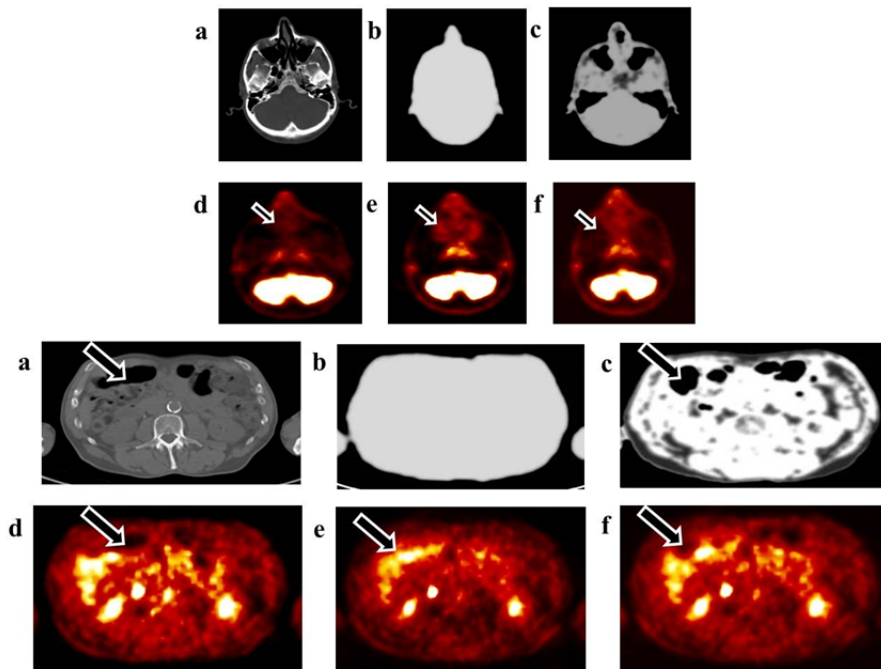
Representative slice showing the impact of neglecting sinus air cavities (top) and air pockets in the abdomen (bottom) in the 3-class attenuation map. (A) CT, (B) MRAC3c attenuation map, (C) MRAC4c attenuation map, (D) PET-CTAC, (E) PET-MRAC3c, and (F) PET-MRAC4c. SUVs measured in sinus cavities and air pockets are 0.80 and 0.41 SUV_{mean} on PET-CTAC, 1.40 and 1.42 SUV_{mean} on PET-MRAC3c, and 0.60 and 0.32 SUV_{mean} on PET-MRAC4c, respectively.
